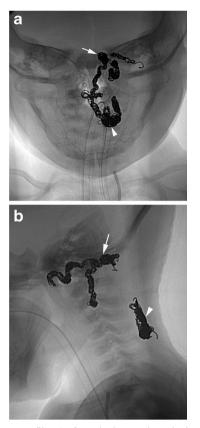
Plain X-ray film (a frontal view, b lateral view) shows the deposited coils in the left hypoglossal canal (*arrows*) as well as the feeding arteries and in the posterior nuchal region (*arrowheads*)
